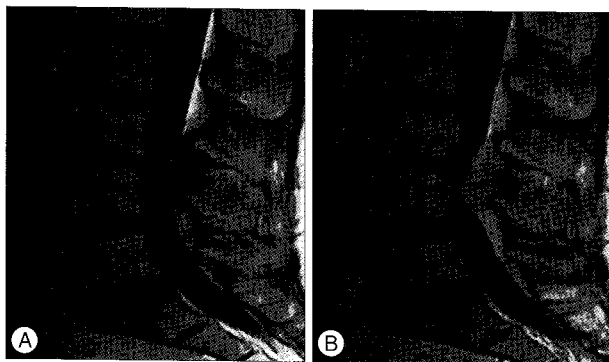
The preoperative MRI of case 2. A : T1-weighted magnetic resonance (MR) image shows an elongated high- or iso-intensity signal mass compressing the thecal sac at the L3-4 dorsal side. B : MRI with gadolinium enhancement shows that a highly enhanced dorsal side mass is compressing thecal sac and this mass seems to be in the epidural space.
